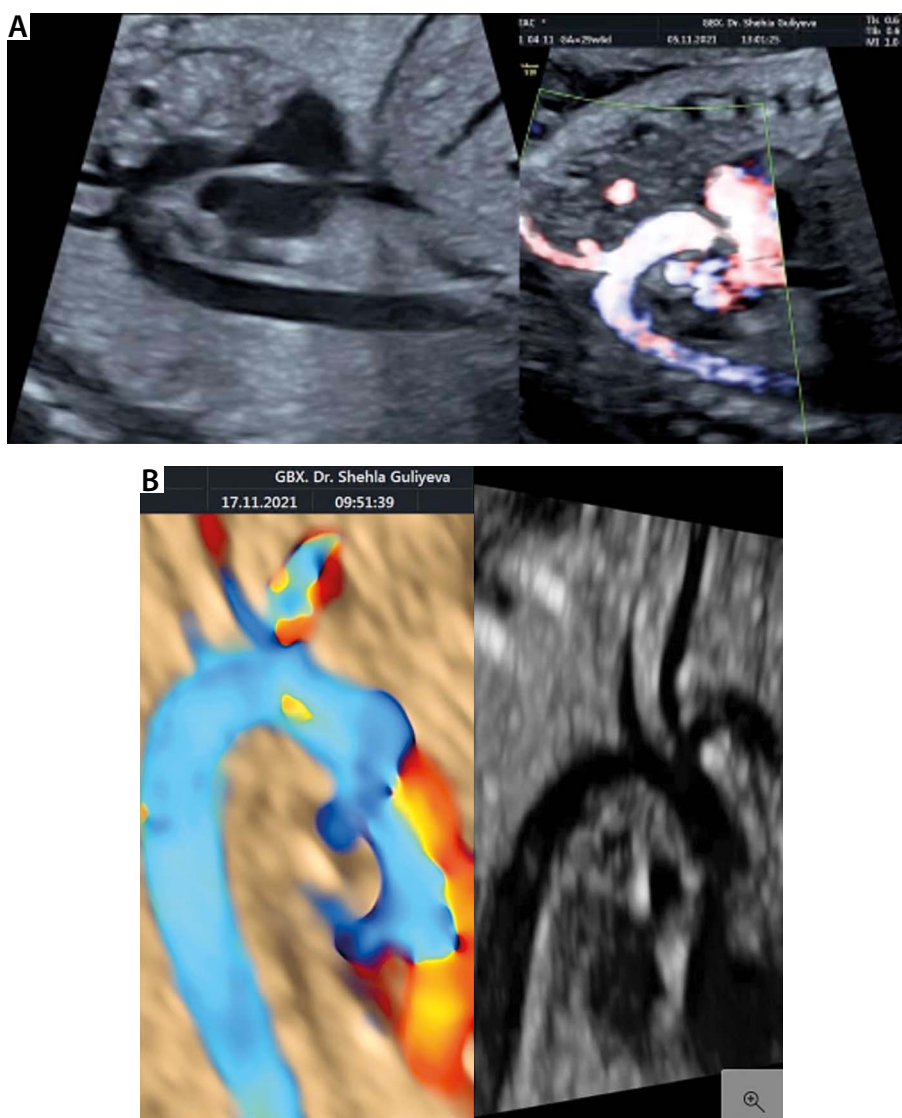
Branching of the aortic arch detected in the sagittal plane, when both ascending and descending aorta were visible. Branching demonstrated with B-mode greyscale imaging and confirmed with power Doppler imaging (A) or colour Doppler imaging (B). Images acquired during fetal rest in the absence of fetal movement
